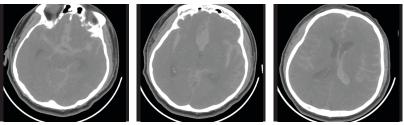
Initial CT scan showing subarachnoid and intraventricular haemorrhage
